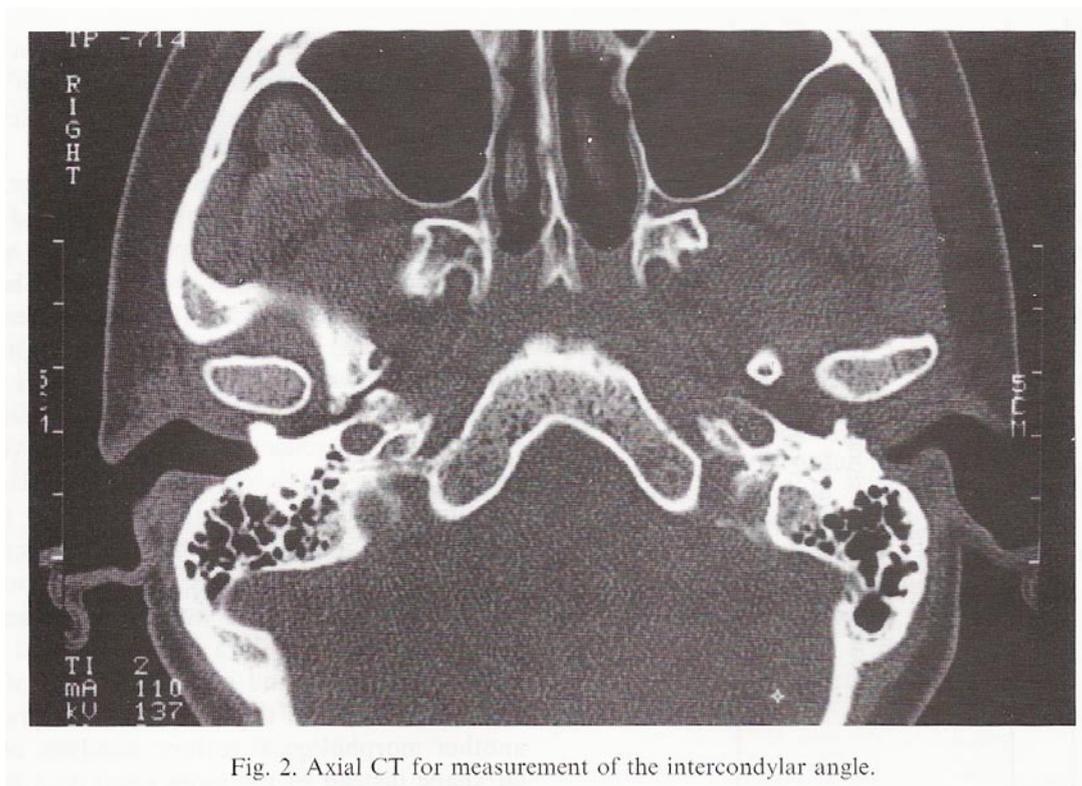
Axial CT for measurement of the intercondylar angle.
